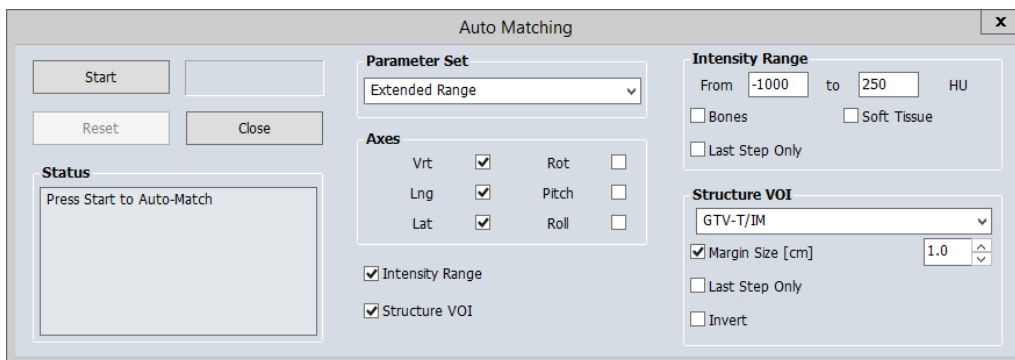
Soft tissue auto match settings for image registration between rCT and CBCT.
